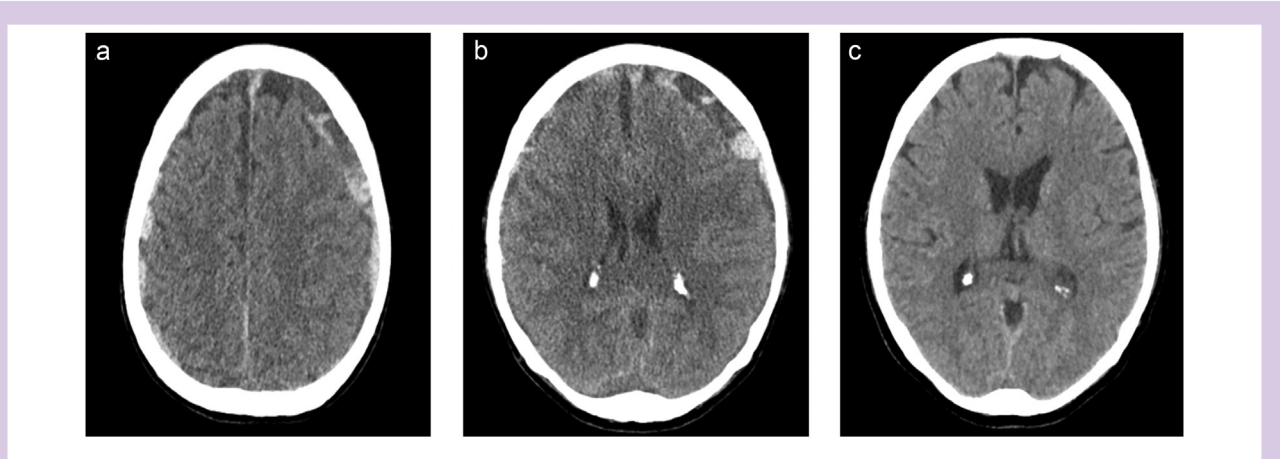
(a) Pre-epidural fibrin glue patch CT head scan. Bilateral subdural haematomas (left greater than right) with brain sagging. (b) One-day post-epidural fibrin glue patch CT head scan. Stable size of bilateral subdural haematomas. (c) Three-months post-epidural fibrin glue patch CT head scan. Interval resolution of bilateral subdural haematomas.
